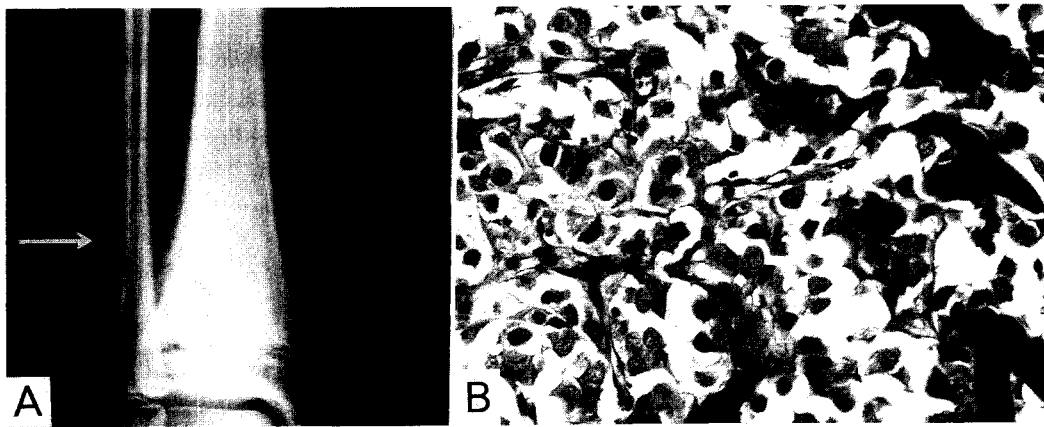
Case 3. A: Plain radiograph at the first visit revealing periosteal reaction of the distal metaphysis of the right tibia (arrow). B: Characteristic osteoblastic pattern with osteoid formation (H. E., $\times 200$).
